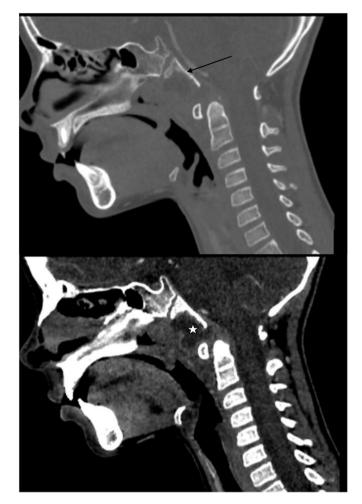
Initial imaging. CT scan, sagittal view showing osteolysis (bone window CT scan) [black arrow] and retropharyngeal abscess [*].
